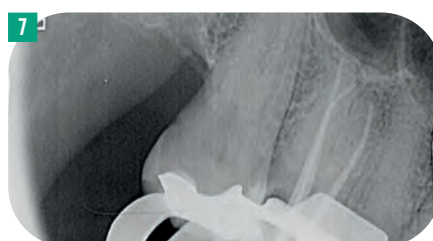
Cone fit radiograph prior to obturation
